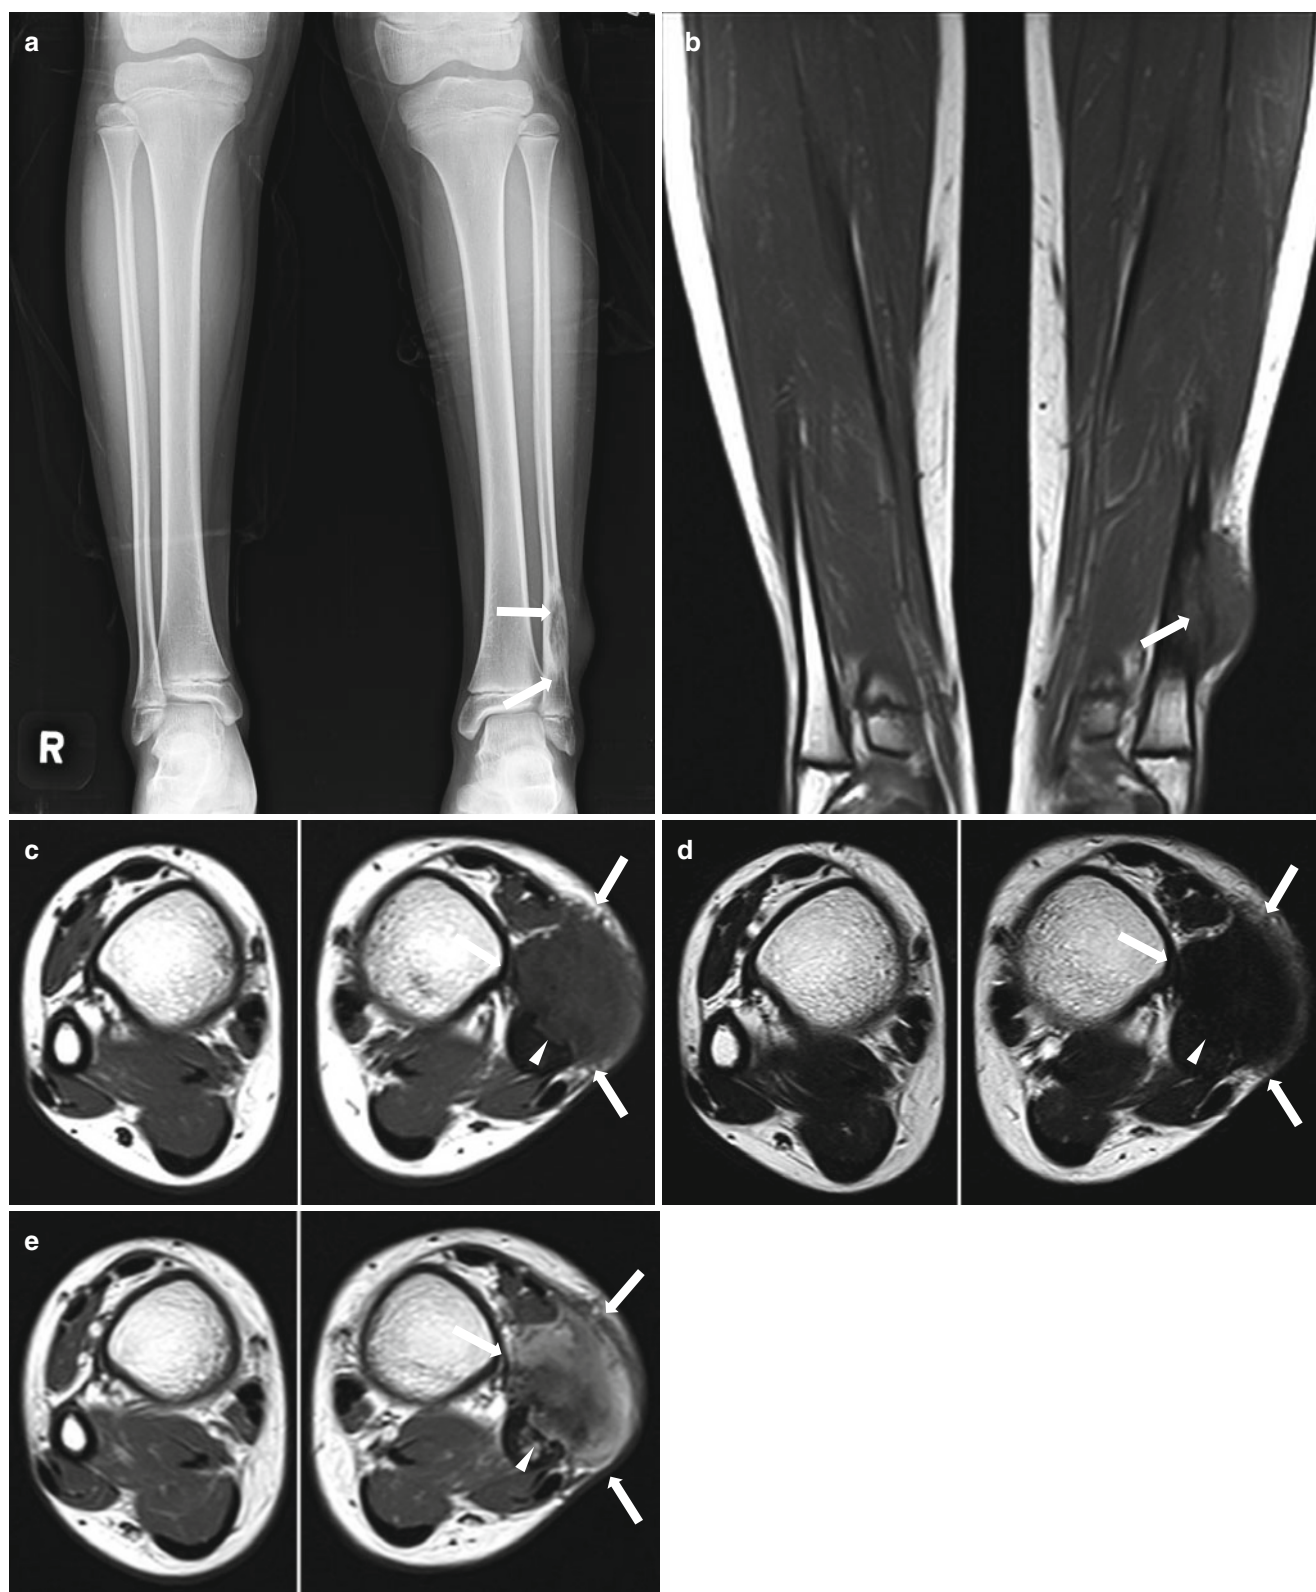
Sclerosing epithelioid fibrosarcoma in lower leg of a 10-year-old boy. (a) Radiography of the lower leg reveals a soft tissue mass density and an osteolytic lesion of the adjacent distal fibular meta-diaphysis (arrows). (b) Coronal T1-weighted MR image shows invasion of fibula by the mass (arrow). (c, d, e) Well-defined soft tissue
